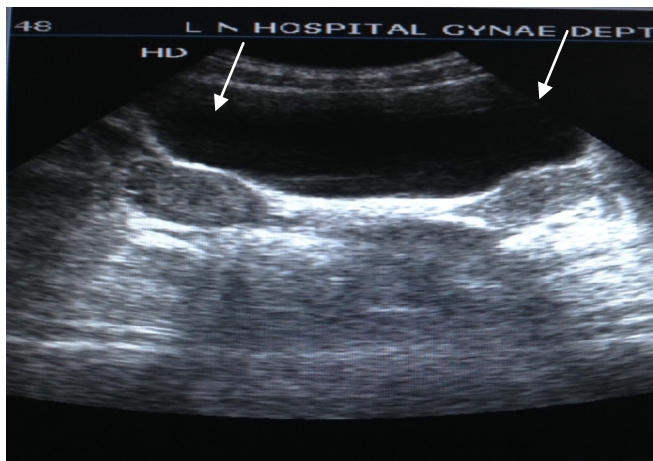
Ultrasound picture showing presence of two uteri.
